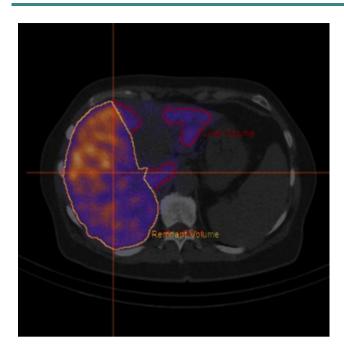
Regional distribution of liver function assessed with hepatobiliary scintigraphy
